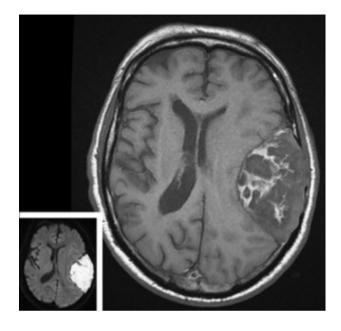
A tight squeeze with an intracranial epidermoid brain tumour. (A) CT scan shows large lesion has not changed since original CT scan (B) and MRIs (C and D) undertaken at the time of the initial diagnosis: the T1-weighted MRIs shows strands of high signal in the lesion-possibly representing fat. The diffusion-weighted MRI shows and confirms the diagnosis ofanepidermoid cyst (E).
